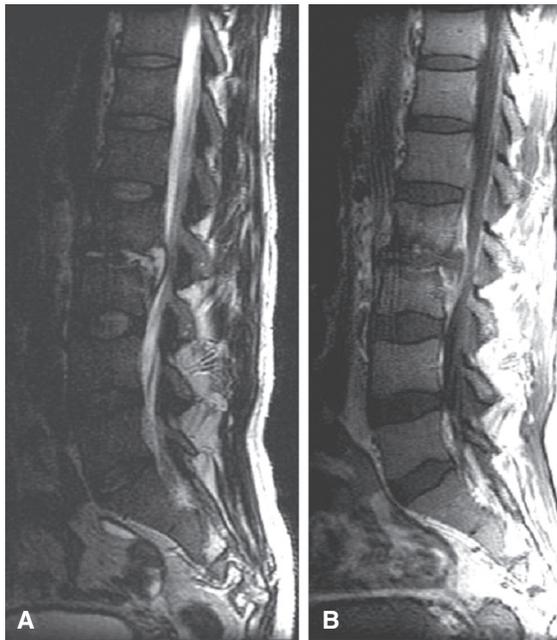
Epidural abscess. A and B, Magnetic resonance images of the lumbosacral spine show a lesion in the epidural space compressing the thecal sac. (Courtesy of Drs. Martin Pomper and Dima Hammoud, Johns Hopkins University.)
